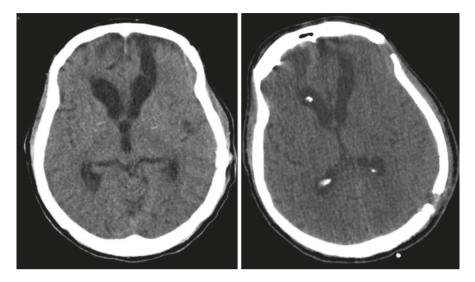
Noncontrast CT head after placement of a right frontal external ventricular drain reveals decreased size of the lateral ventricles
